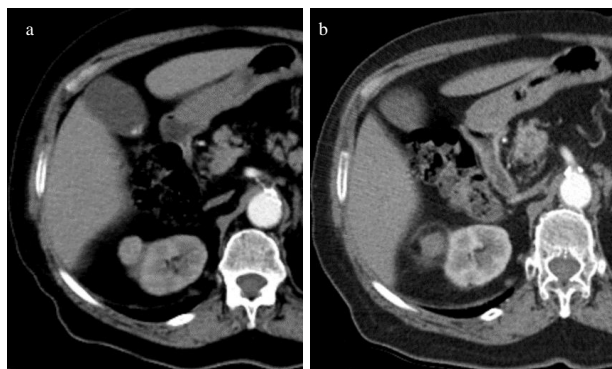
a. Preoperative CT image shows exophytic contrast enhanced mass on right kidney b. Postoperative 18. months CT image shows no contrast enhancement on the mass
